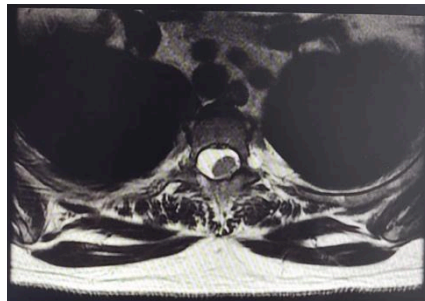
A well-defined hyperintense mass is seen at the T2–T3 level on axial T2-weighted non-contrast MRI of the thoracic spine. The lesion causes asymmetric spinal cord deformity, with the cord displaced to the right.
